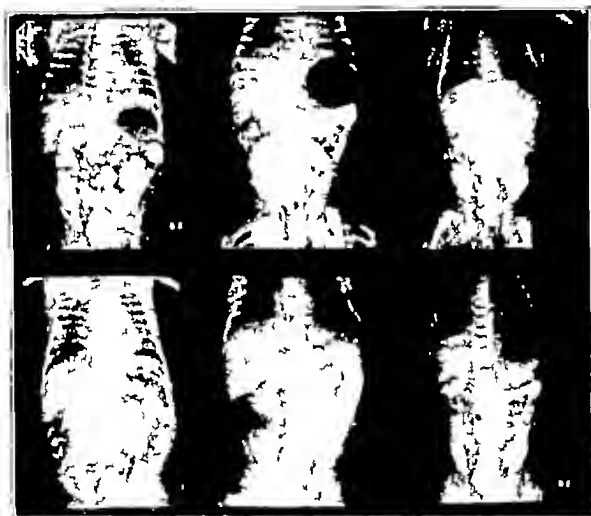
Roentgenograms of colons after barium enema.
